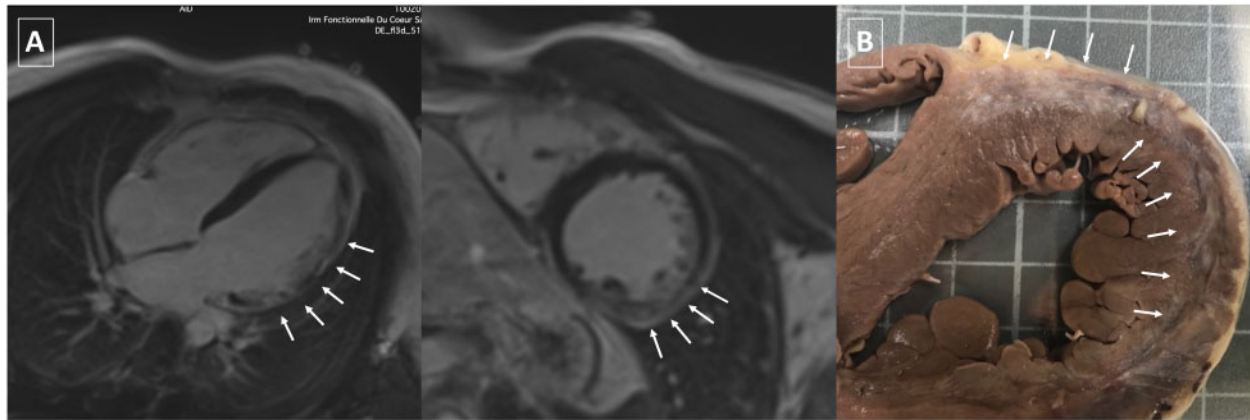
Confirmation of myocardial fibrosis in both rugby players displaying life-threatening ventricular arrhythmias. (A) Cardiac magnetic resonance imaging (1.5 T) of Case 1 rugby player. The presence of a sequela of myocarditis (arrows) can be observed on the inferolateral wall with myocardial thinning. (B) Macroscopic image after fixation in formalin. Presence of an area of old whitish-coloured fibrosis mainly involving the anterior ventricular septum, the anterior and lateral aspect of the left ventricle, at the epicardial and myocardial levels.
